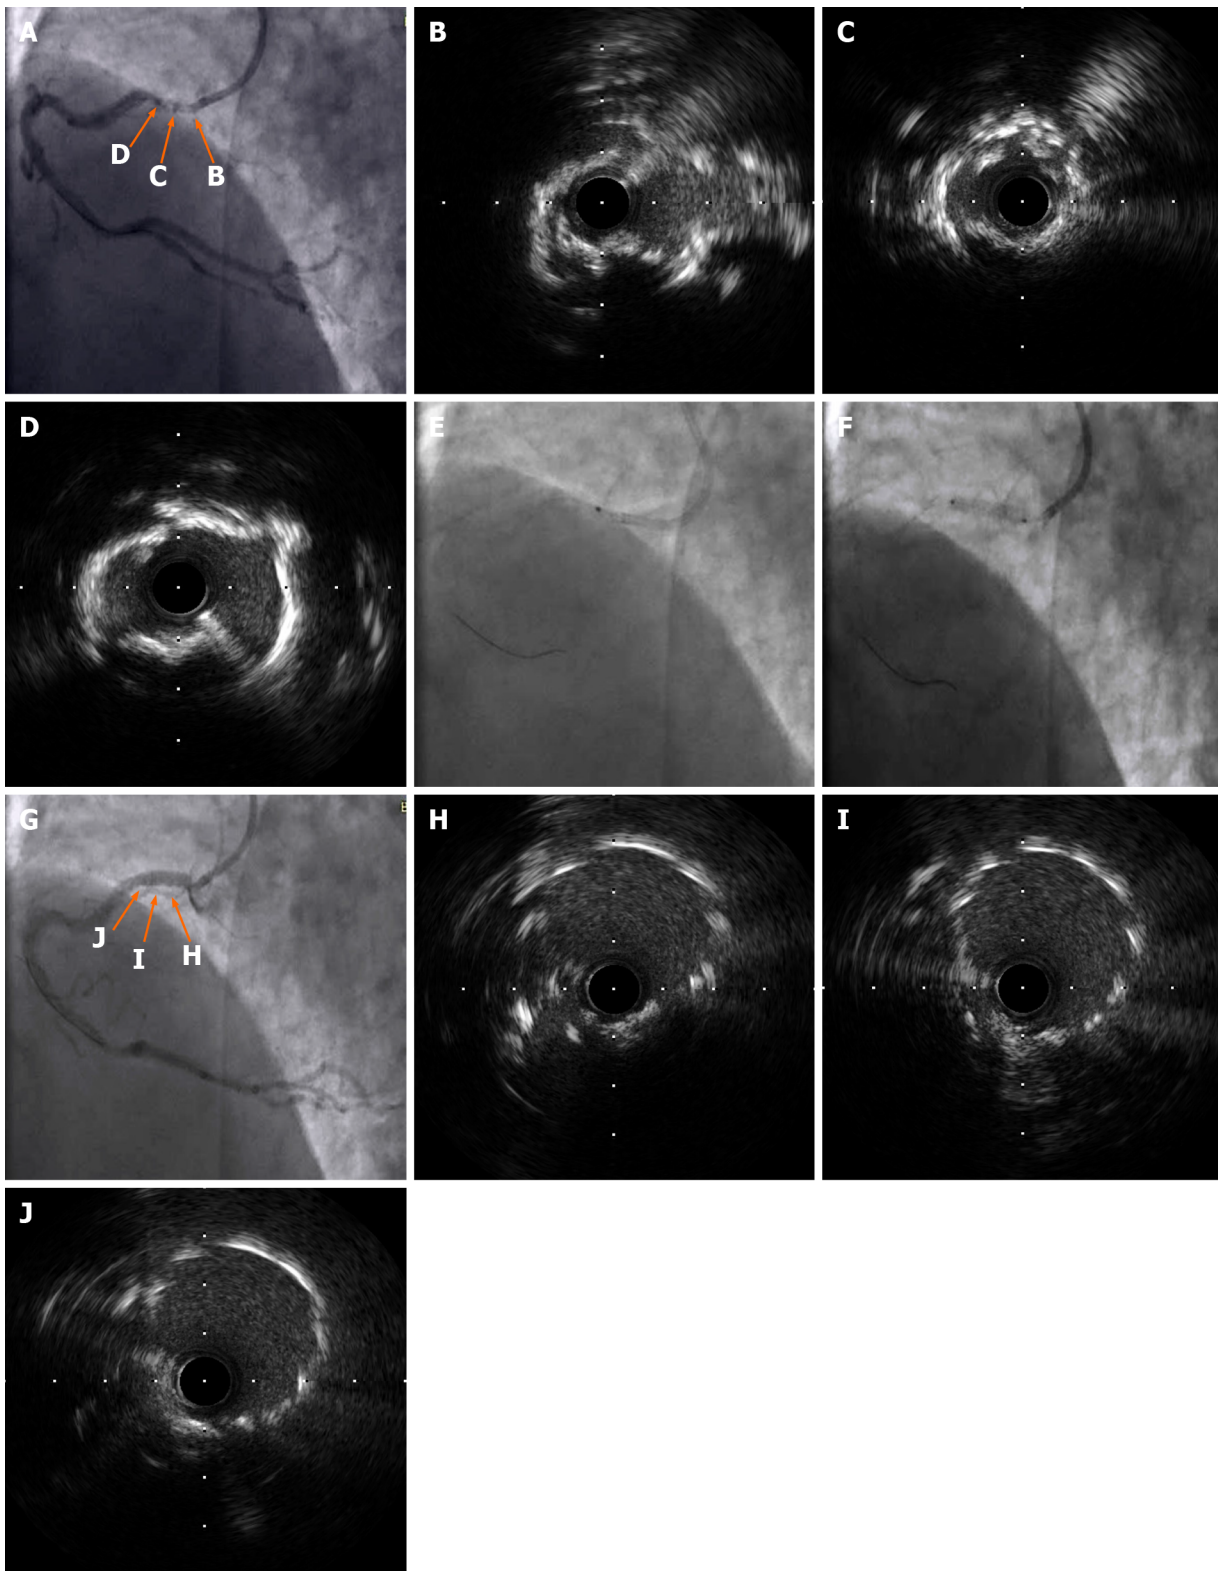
Intravascular ultrasonography findings. A–D: Intravascular ultrasonography (IVUS) was performed after the laser catheter passed through the lesion and severe calcifications were noted; E and F: The laser catheter was slowly passed through the lesion and the stent was placed at 12 atm; G–J: The final IVUS findings showed no apparent dissection, malapposition, or underexpansion.
